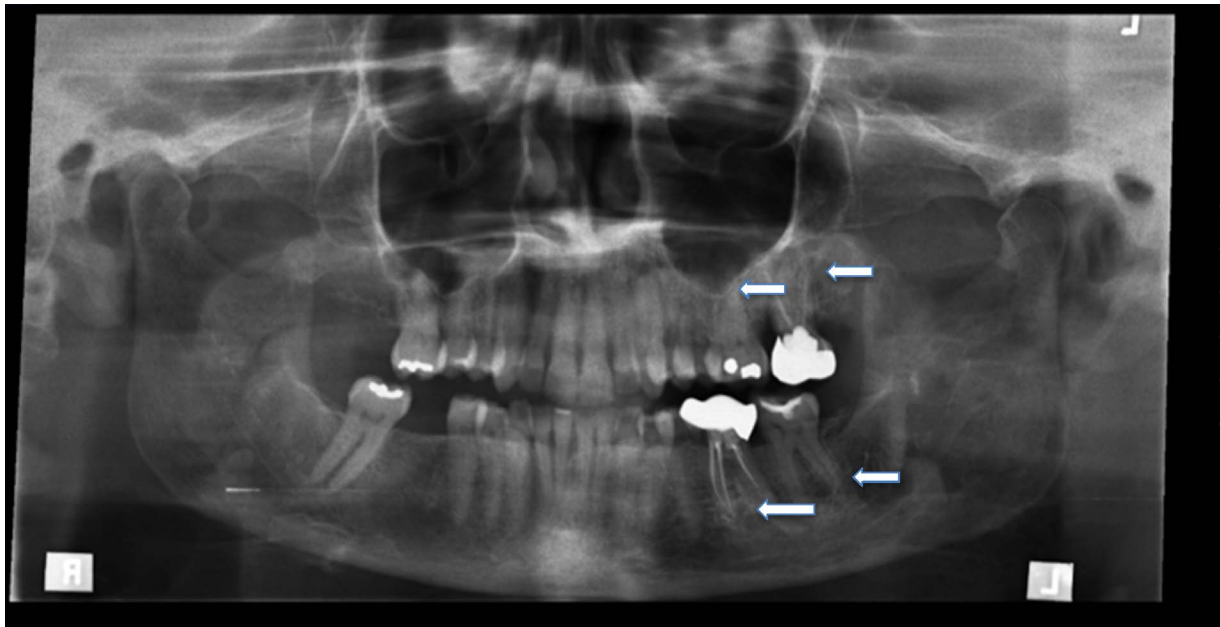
Fig. 1 depicts the panoramic x-ray taken on admission to the hospital. Periapical radiolucencies are evident within teeth numbers 14, 15, 18, and 19 (white arrows).
